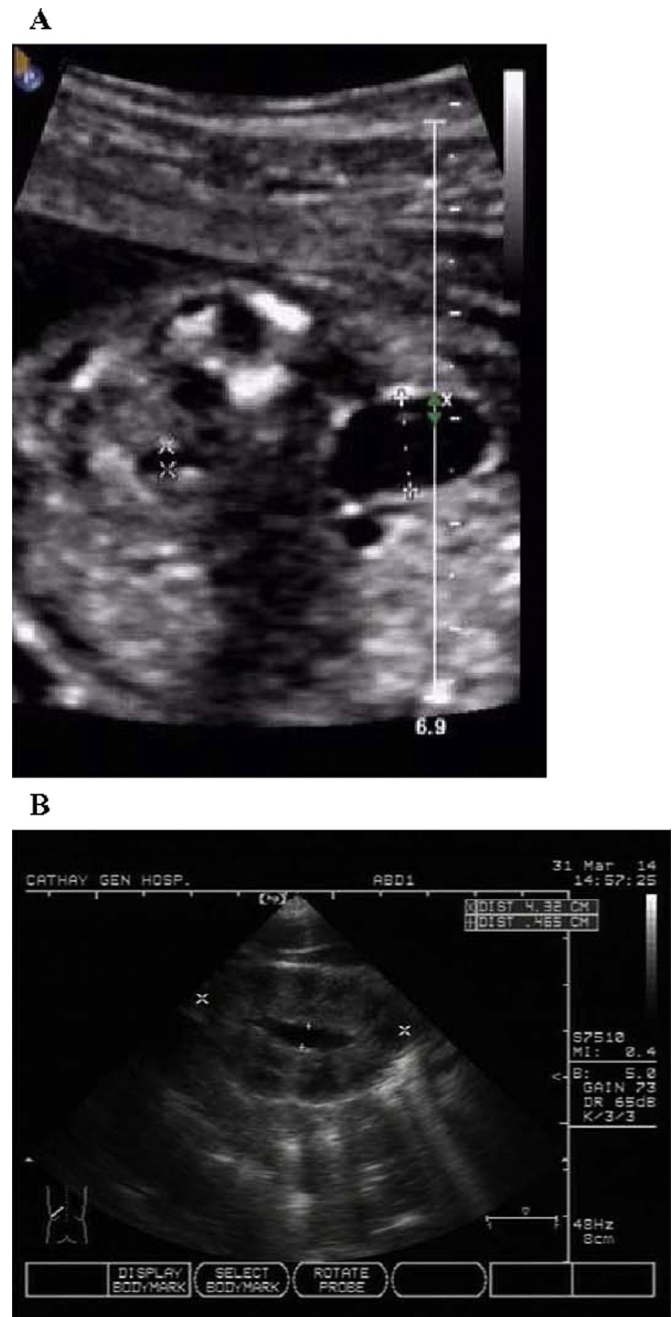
Representative figures of: (A) prenatal fetal ultrasound showing a fetus with hydronephrosis, and a transverse view of bilateral kidneys with the fetus in the prone position; and (B) postnatal ultrasound measurement of anterior–posterior renal pelvis diameter. Longitudinal view of one kidney. The renal pelvic diameter measured from the inner border of the anterior side of the renal pelvis to the inner border of the posterior side was > 3 mm.
